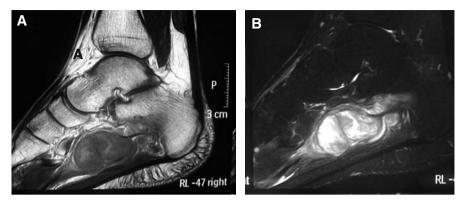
Schwannoma associated to neurofibroma in the right foot of a NF1 patient. Sagittal T1-weighted MRI image without (A) and with (B)
